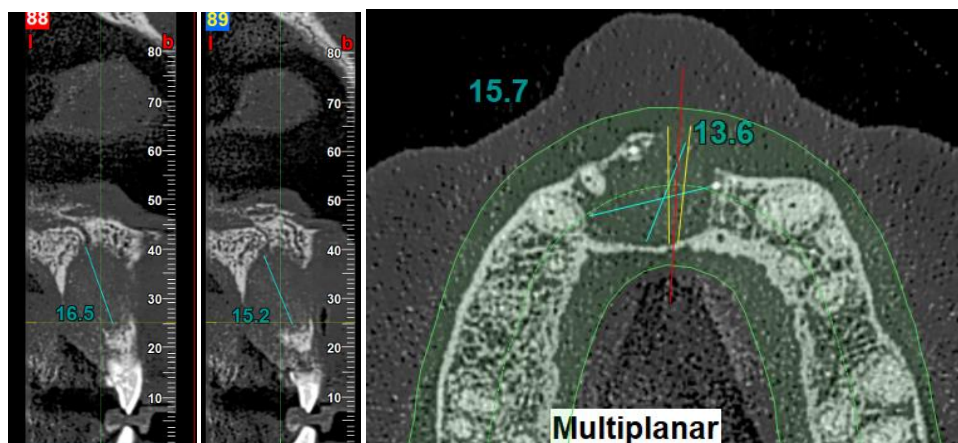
3 month follow up CBCT images
